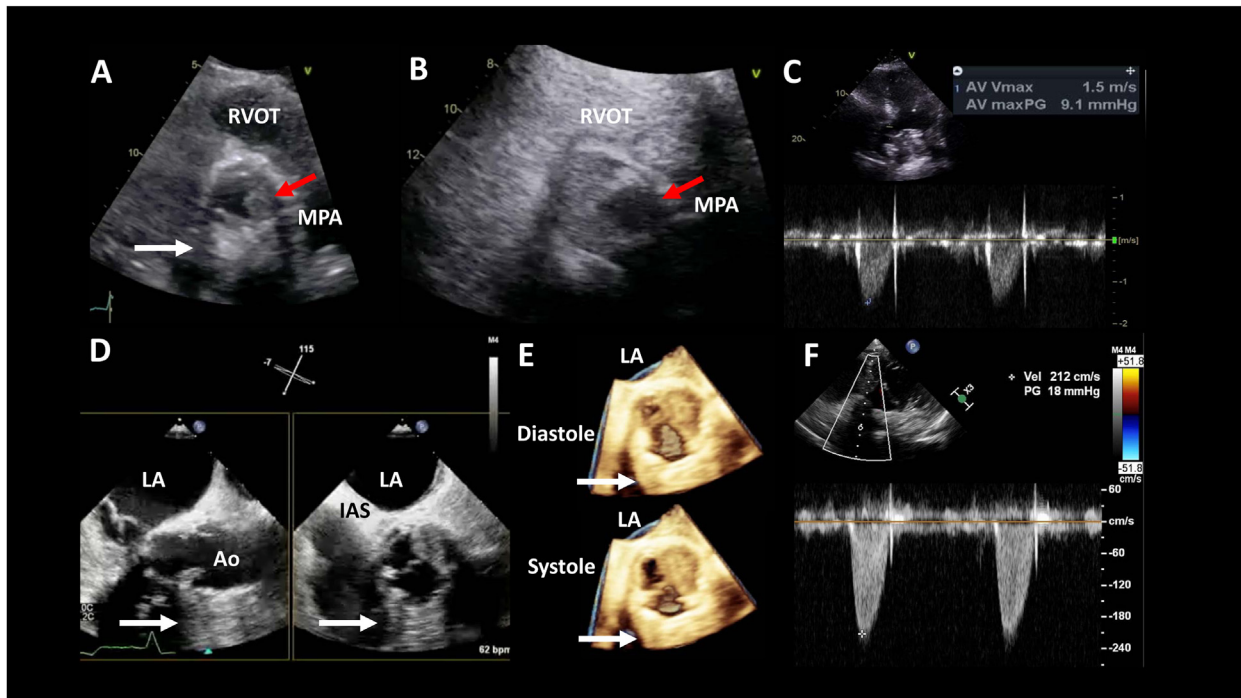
A case of bioprosthetic aortic valve thrombus. (A) Transthoracic echocardiographic parasternal short-axis image of the aortic valve during systole demonstrates shadowing of the posterior structure (*white arrow*). Note that there is failure of the left coronary cusp to open because of a mass (*red arrow*). (B) The administration of ultrasound-enhancing agent reveals that this mass is likely a thrombus. (C) CW Doppler in the apical five-chamber view demonstrating a normal peak systolic gradient of 9 mm Hg. (D) TEE performed a few days later allows clear visualization of the posterior annulus. However, there is artifact obscuring the anterior annulus (*white arrow*). It also shows in the long-axis view that the right coronary cusp is now thickened (*left*), and in the short-axis view obtained through biplane, it does not open fully during systole (*right*). (E) Three-dimensional transesophageal echocardiographic rendering of the aortic valve in the short-axis view during diastole (*top*) and systole (*bottom*) demonstrating prosthesis-related shadowing (*white arrow*) and fixation of the left and right coronary cusps. (F) CW Doppler in the transgastric view demonstrates a higher peak systolic gradient of 18 mm Hg. *Ao*, Aorta; *AV*, aortic valve; *IAS*, interatrial septum; *LA*, left atrium; *maxPG*, maximal pressure gradient; *MPA*, main PA; *PG*, pressure gradient; *Vel*, velocity; *Vmax*, maximal velocity.
